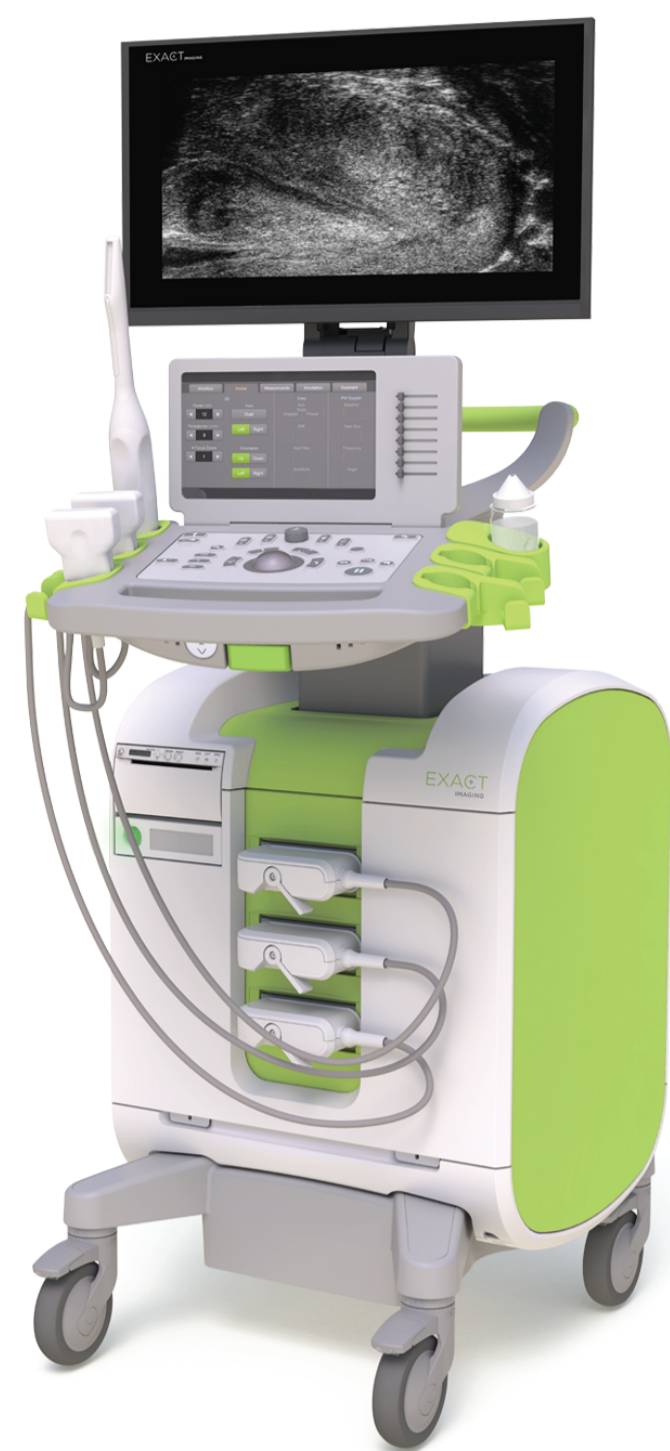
ExactVu™ 29 MHz Micro-Ultrasound System
